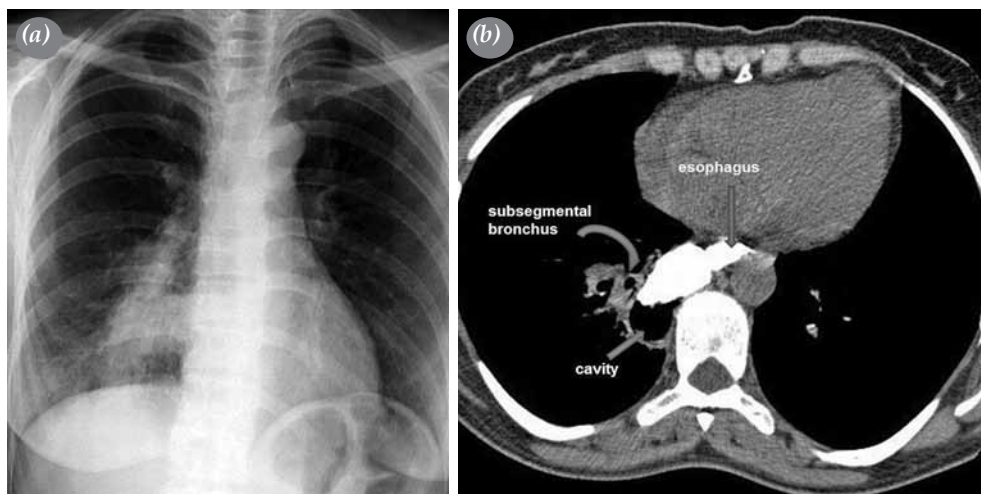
(a) Posteroanterior chest radiograph of the right lung middle zone showing the extending hilum with a radiopaque appearance and reticulonodular opacities in the adjacent lung parenchyma. (b) Oral contrast-enhanced computed tomography in the prone position revealing a cavitary lesion across from the esophagus along with adjacent subsegmental bronchial dilatation.
